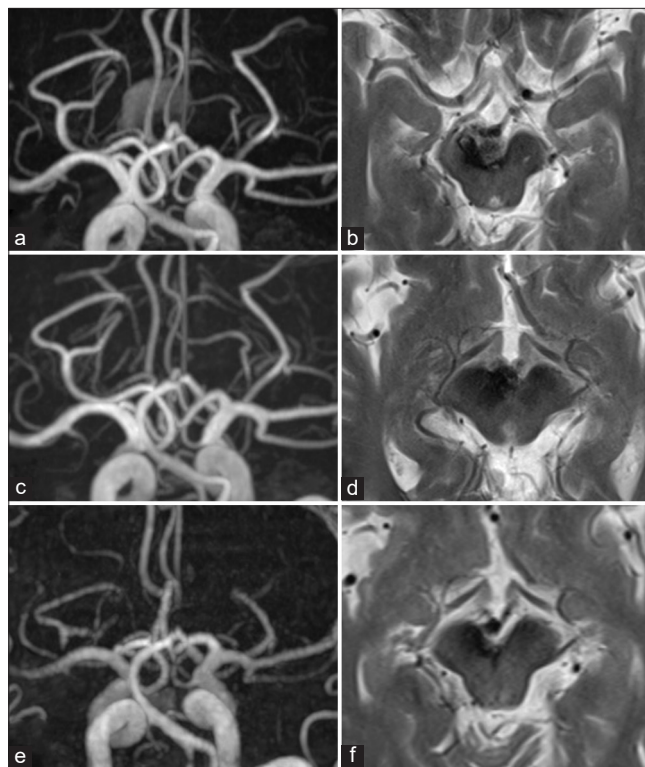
Radiological findings at 2 months (a and b), 6 months (c and d), and 5 years (e and f) after coil embolization. (a) MRA image revealing residual thrombus at the basilar tip. (b) T2WI showing that the thrombus has reduced in size, as has the midbrain compression. (c) MRA image indicating a significant reduction in thrombus at the basilar tip. (d) T2WI confirms the further reduction in midbrain compression as a result of thrombus. (e) MRA image demonstrating the complete disappearance of the thrombus. (f) T2WI shows complete resolution of the midbrain compression. MRA: Magnetic resonance angiography, T2WI: T2-weighted image.
